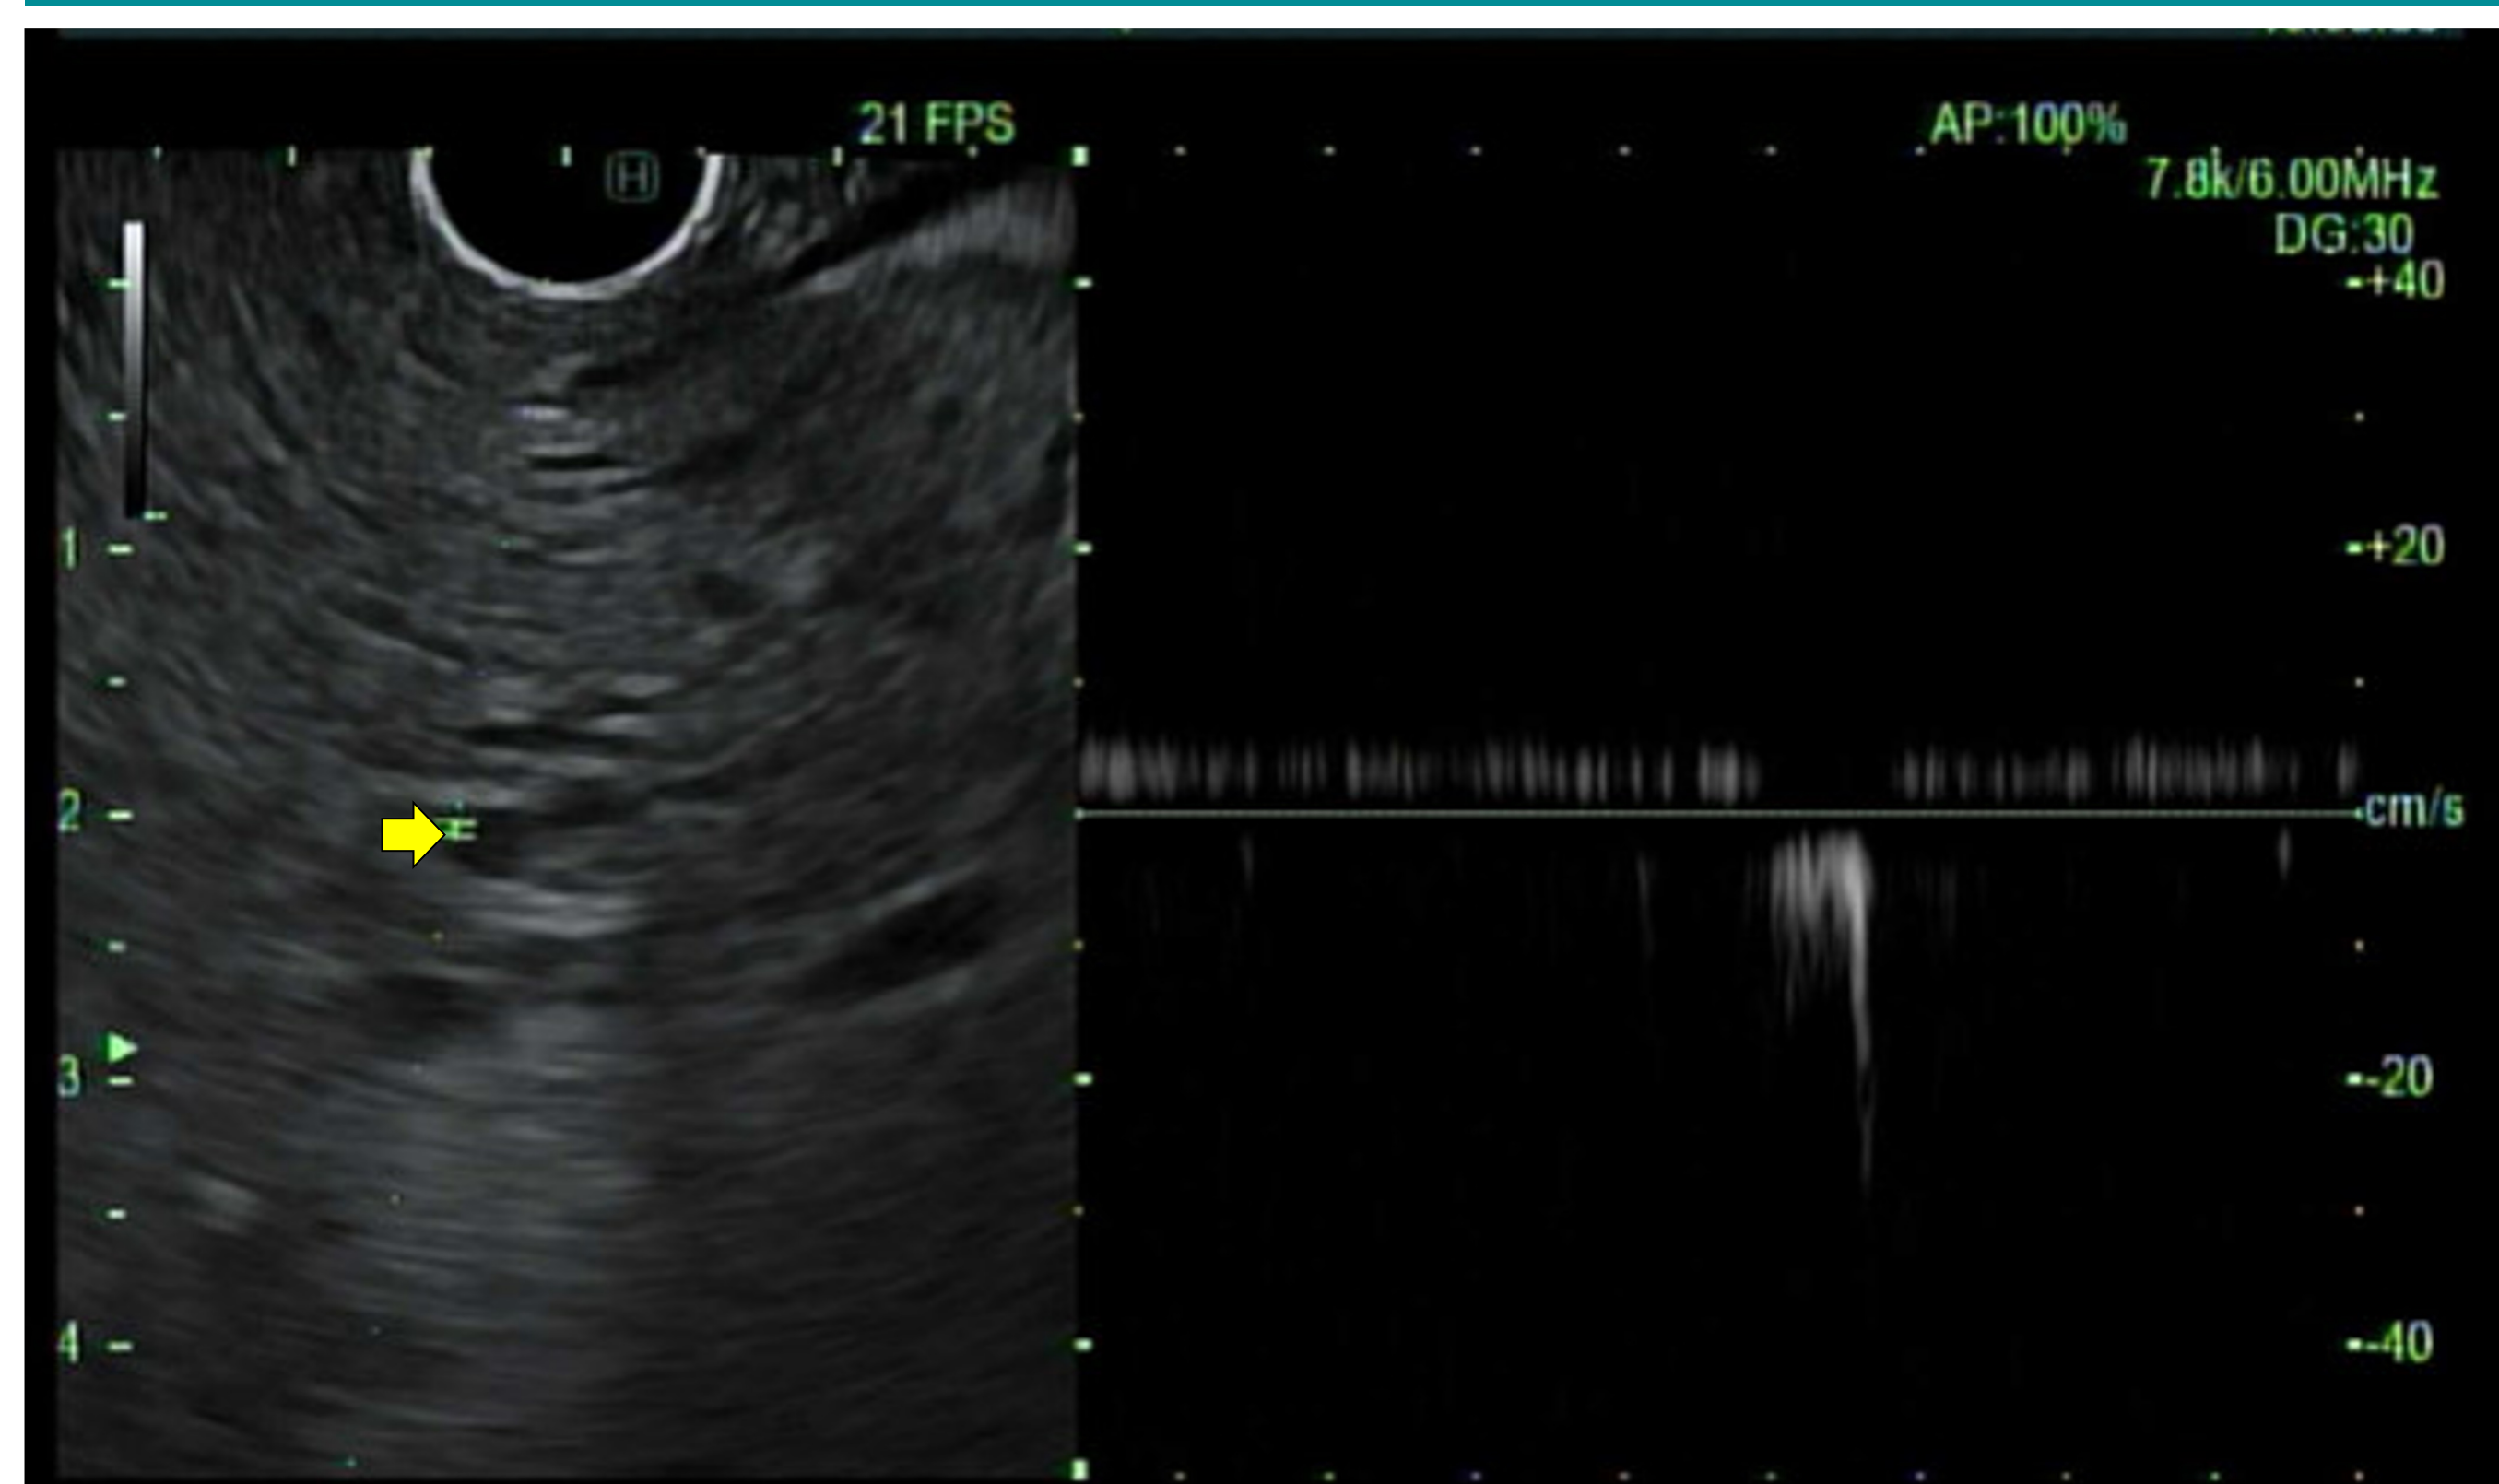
Doppler with portal waveform. Note that liver has honeycomb pattern and heterogenous echotexture.
